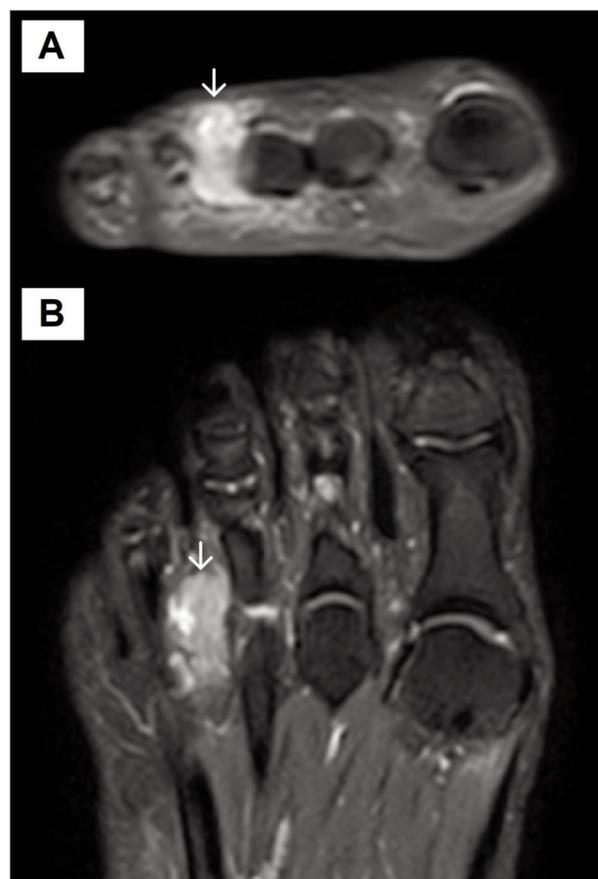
MRI (STIR sequence, coronal (A) and axial (B) views) of the right forefoot, identifying a mass in the third intermetatarsal space (white arrow).
